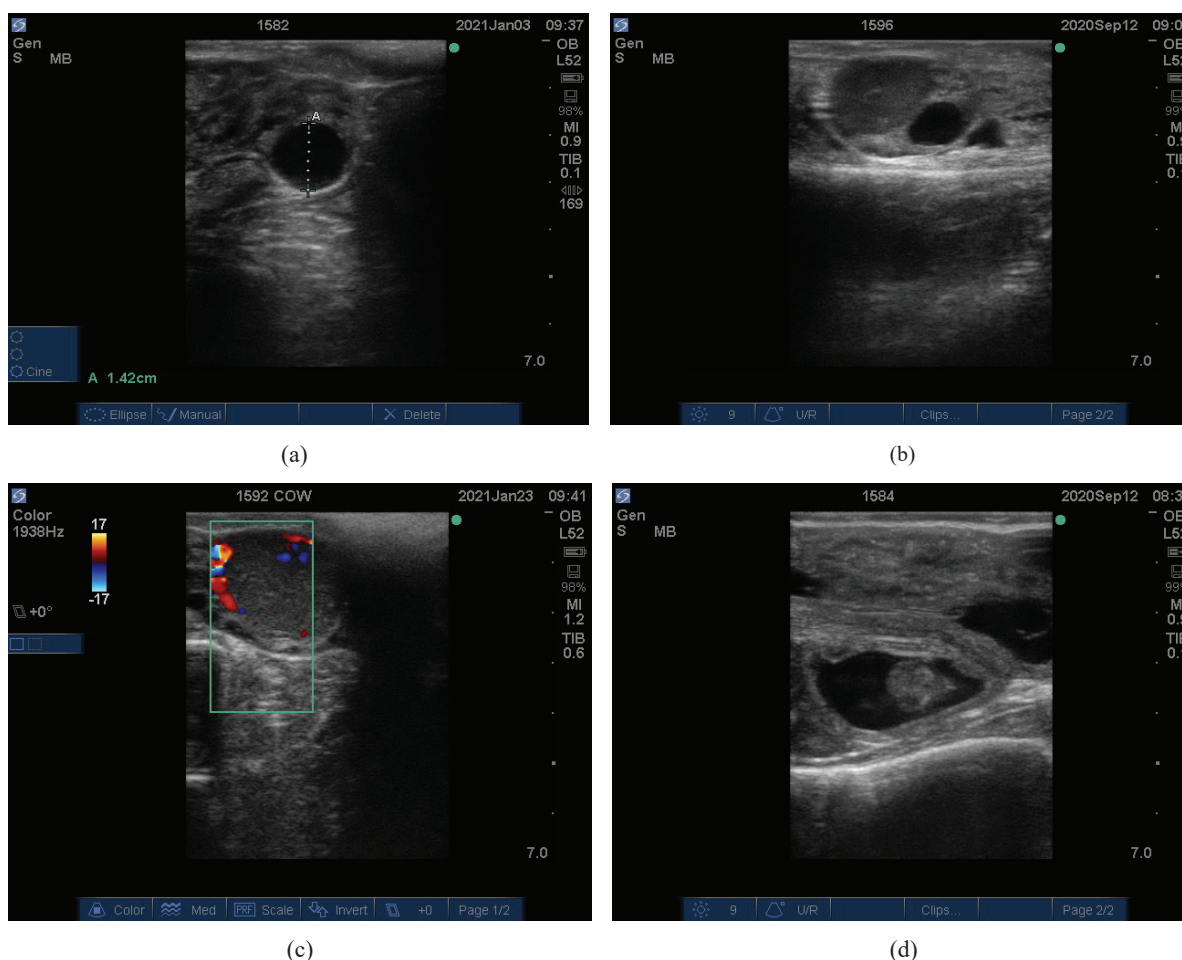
Representative ultrasonographic images showing (a) pre-ovulatory follicle (POF) on the day of artificial insemination (AI) in B-mode; (b) follicle and corpus luteum (CL) on day 14 post-AI in B-mode; (c) colour Doppler image showing luteal blood flow on day 21 post-AI; and (d) ultrasonographic confirmation of pregnancy on day 47 post-AI.
